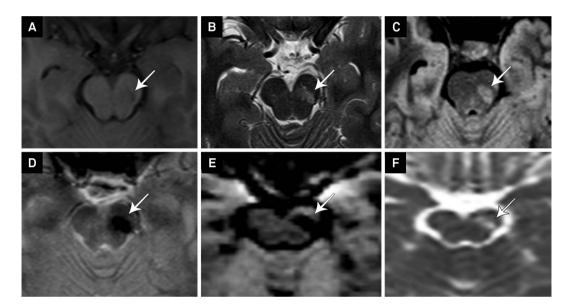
(A): MRI scan exhibits a focal lesion in the left pontomesencephalic junction, characterized by subtle hypointensity on T1-weighted; (B): Hyperintensity on T2-weighted; (C): FLAIR; (D): Marked low signal intensity on T2*-GRE images; (E): DWI shows low signal intensity with corresponding high signal intensity on (F): ADC map. All images are in the axial plane and focused in the area of interest. The finding of low signal intensity on T2*-GRE sequence (or, alternatively, SWI) along with high signal on FLAIR and T2-weighted images derives from the paramagnetic effect of deoxyhemoglobin (resultant from sluggish flow), instead of hemosiderin or calcification. Low signal intensity on DWI is a very characteristic feature and rules out other differential diagnosis, such as acute infarction.
